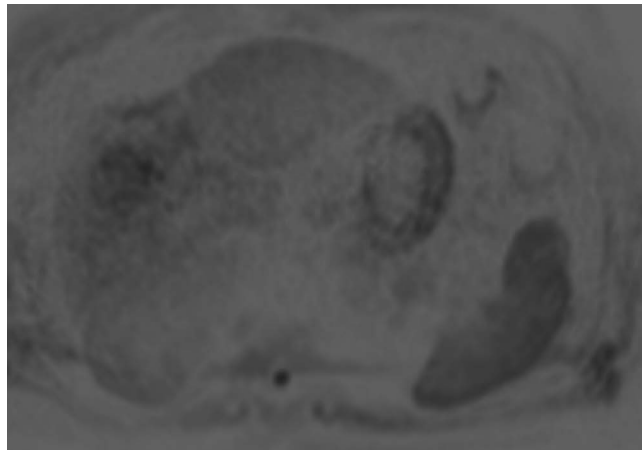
Liver. MRI. Diffusion weighted imaging (DWI) (inverted grayscale). b=500. Axial plane.
